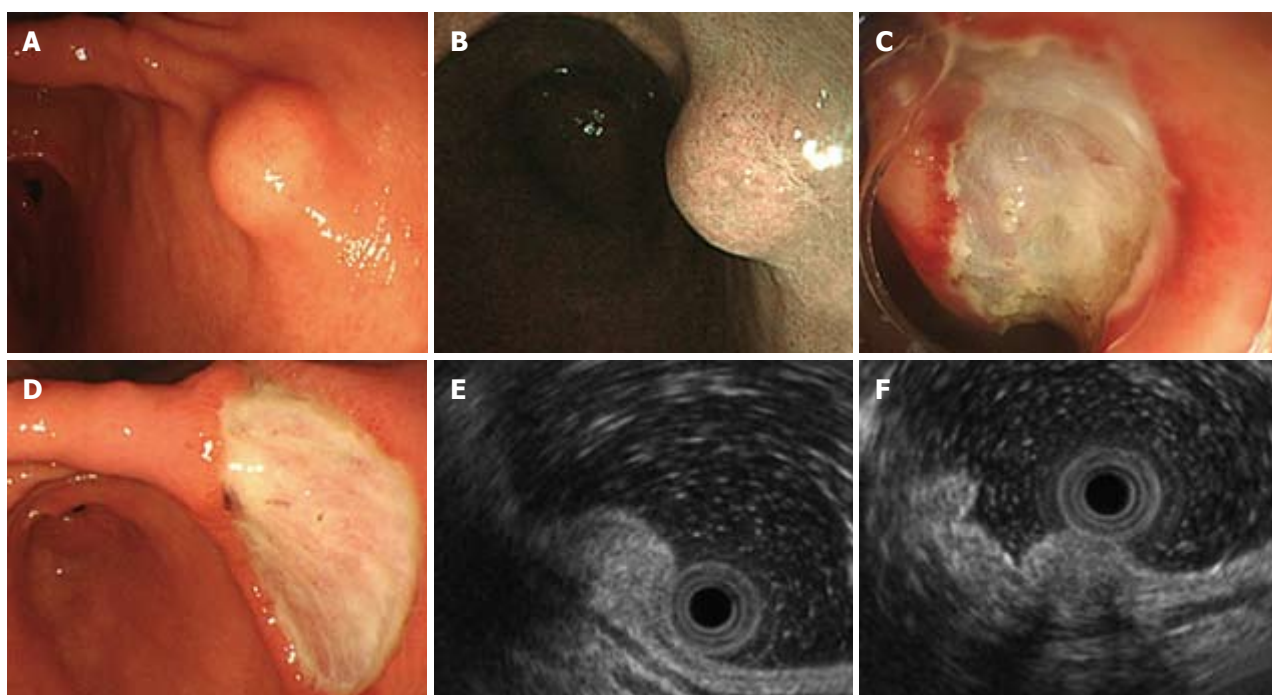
Endoscopic ultrasonography findings of visualized submucosal tumor. A: Endoscopy shows 10-mm shows submucosal tumor (SMT) in lesser curvature of lower corpus of stomach; B: Narrow-band endoscopic imaging SMT covered by normal gastric mucosa; C: Endoscopic submucosal dissection (ESD) for SMT; D: Stomach ulceration five days after ESD; E: Endoscopic ultrasonography (EUS) findings show internally isoechoic, homogeneous sub-mucosal tumor mainly localized within second and third layers, whereas first and fourth layers are preserved; F: Acoustic shadowing of hyperechoic foci inside lesion is consistent with calcifications. Fourth layer is obvious.
